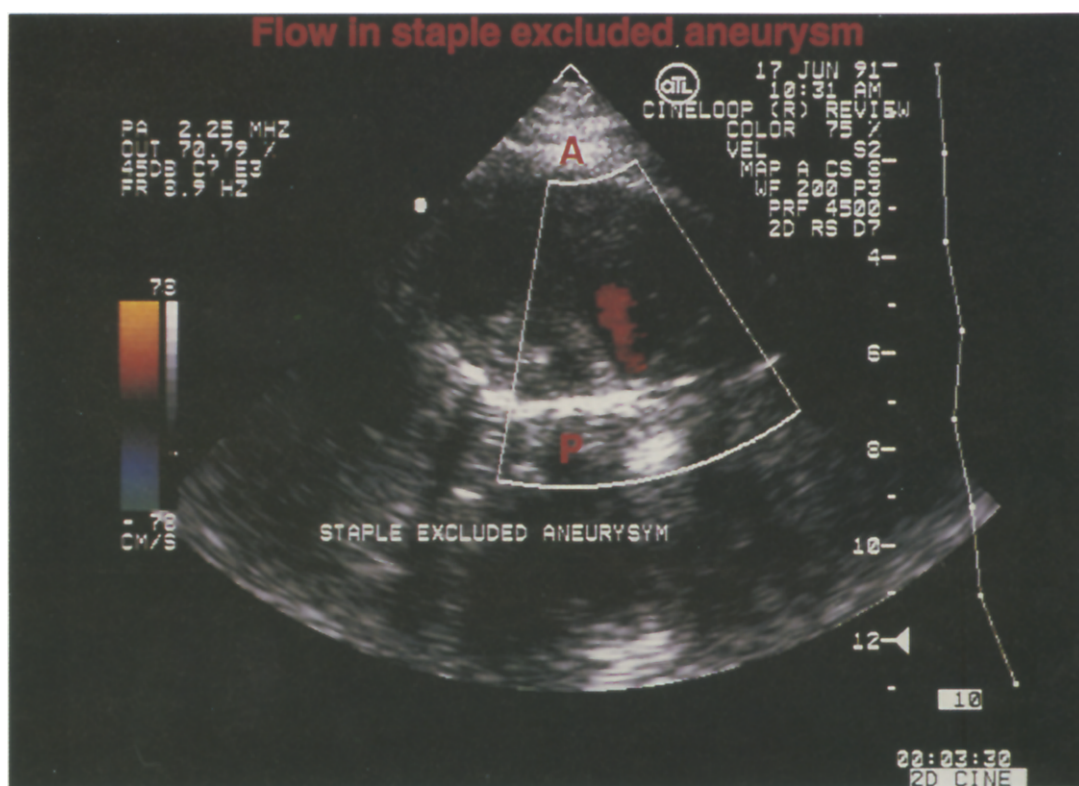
Color flow sonogram of largest area of persistent flow (lumbar artery) noted in series. Thrombosis at 42 months.
